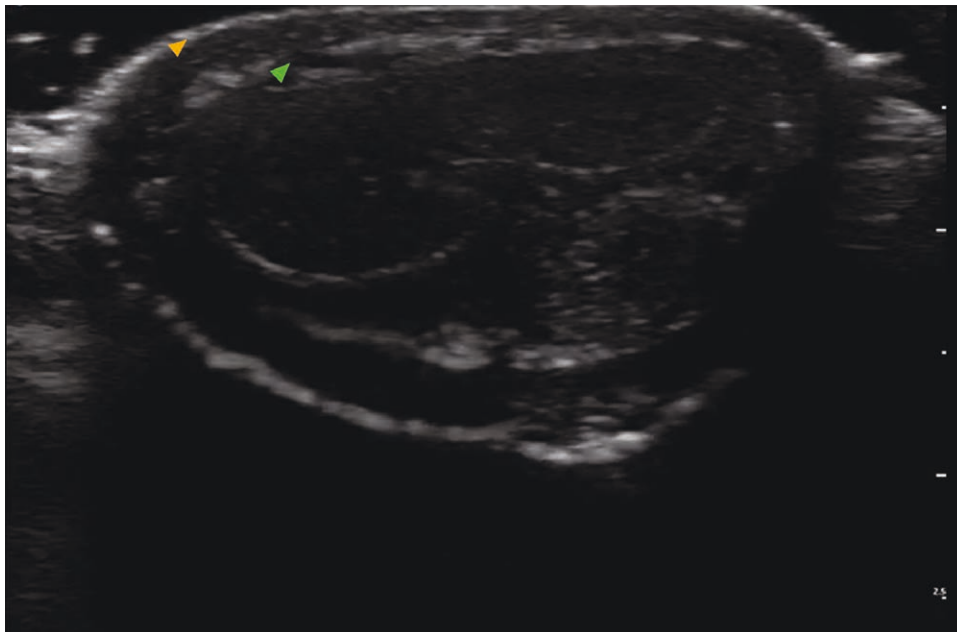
Ultrasound image showing the anatomical plane between the dartos fascia (orange arrow) and Buck fascia (green arrow). The image confirms proper positioning for HA filler placement.
